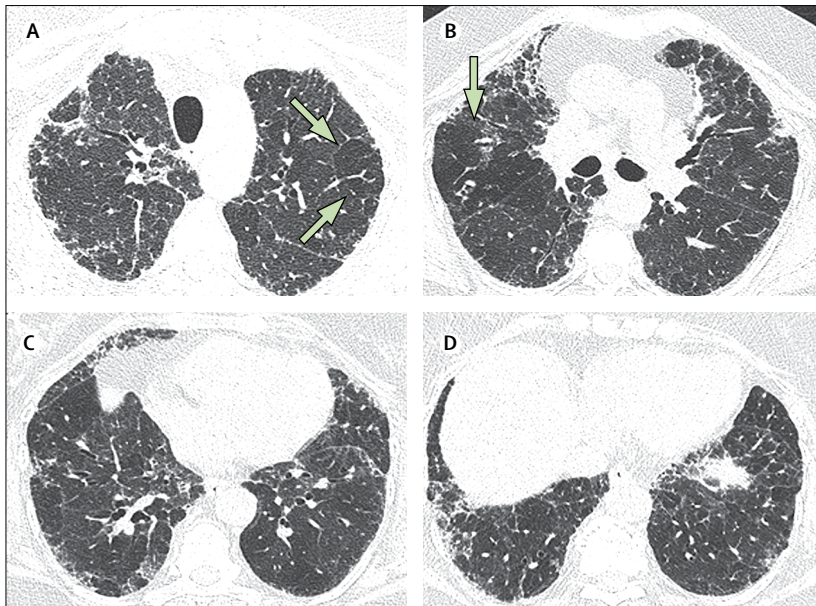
CT pattern indeterminate for UIP
